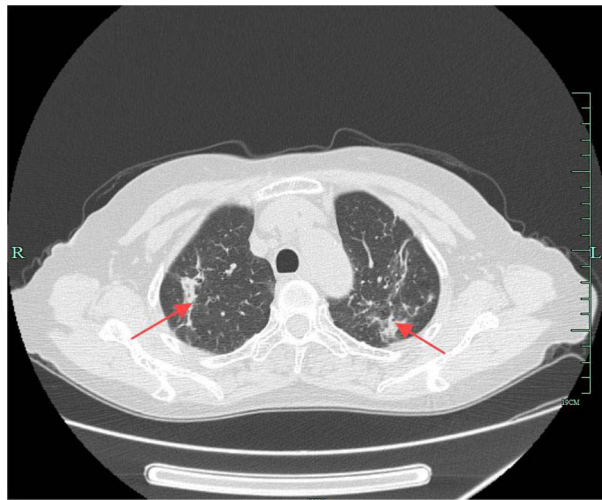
The CT result of the patient's lungs after 9 months of treatment. Red arrows indicate that high-density shadows are significantly absorbed.
